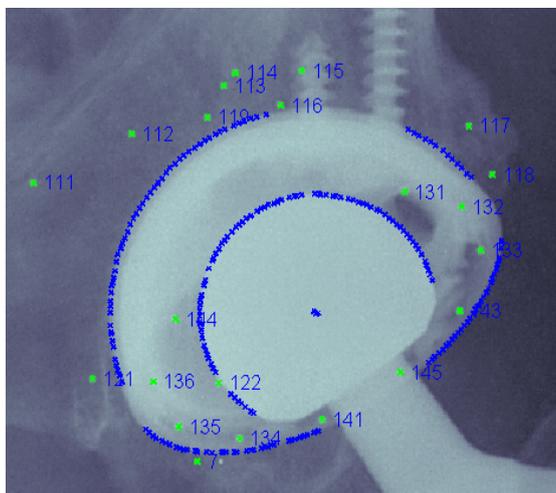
Automated edge detection of the femoral head and acetabular cup, allowing for the utilization of markerless UmRSA. The software populates points on the edge of the head, backshell, and cup opening after manual selection on the radiograph.
